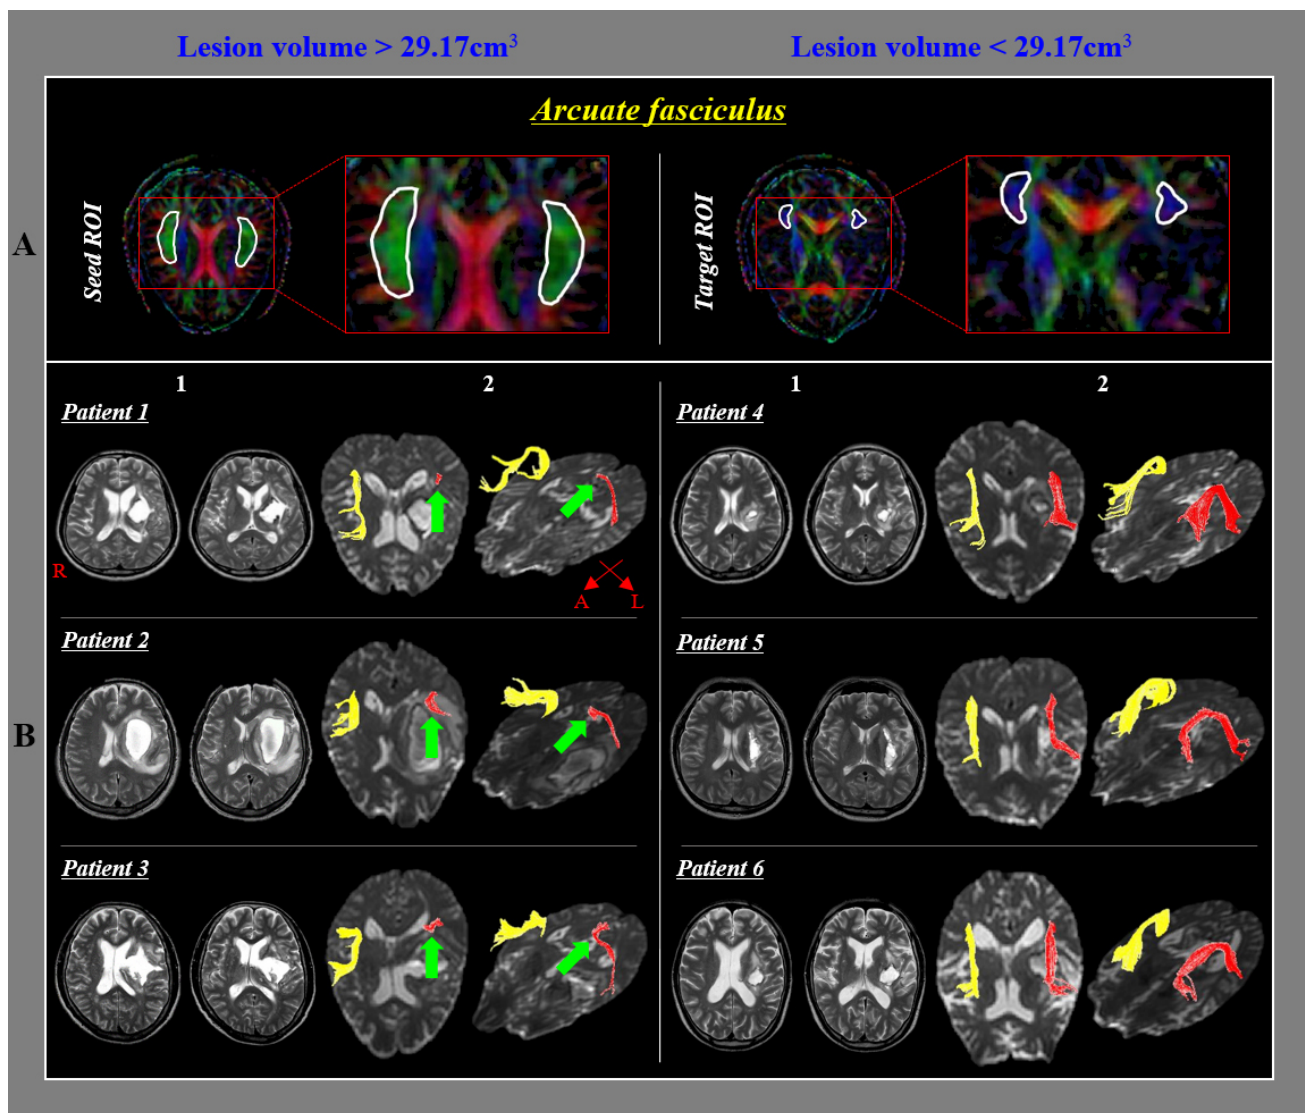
Regions of interest and diffusion tensor tractography for the arcuate fasciculus (AF). (A) The seed and target regions of interest are applied to the posterior parietal area of the superior longitudinal fascicle where the longitudinal aspect of the AF and the posterior temporal lobe are expected. (B) (1) T2-weighted brain magnetic resonance images at the time of diffusion tensor imaging scanning in representative patients with a lesion volume (LV) larger than 29.17 cm³ (patient 1: 43-year-old male, patient 2: 46-year-old male, patient 3: 59-year-old male) and with an LV smaller than 29.17 cm³ (patient 4: 56-year-old male, patient 5: 33-year-old male, patient 6: 63-year-old male). (2) Results of diffusion tensor tractography for the left AF. The left AF in patients with an LV larger than 29.17 cm³ shows discontinuation (green arrow) between Wernicke's and Broca's areas in the dominant hemisphere, whereas the left AF in patients with an LV smaller than 29.17 cm³ shows preservation of AF integrity.
